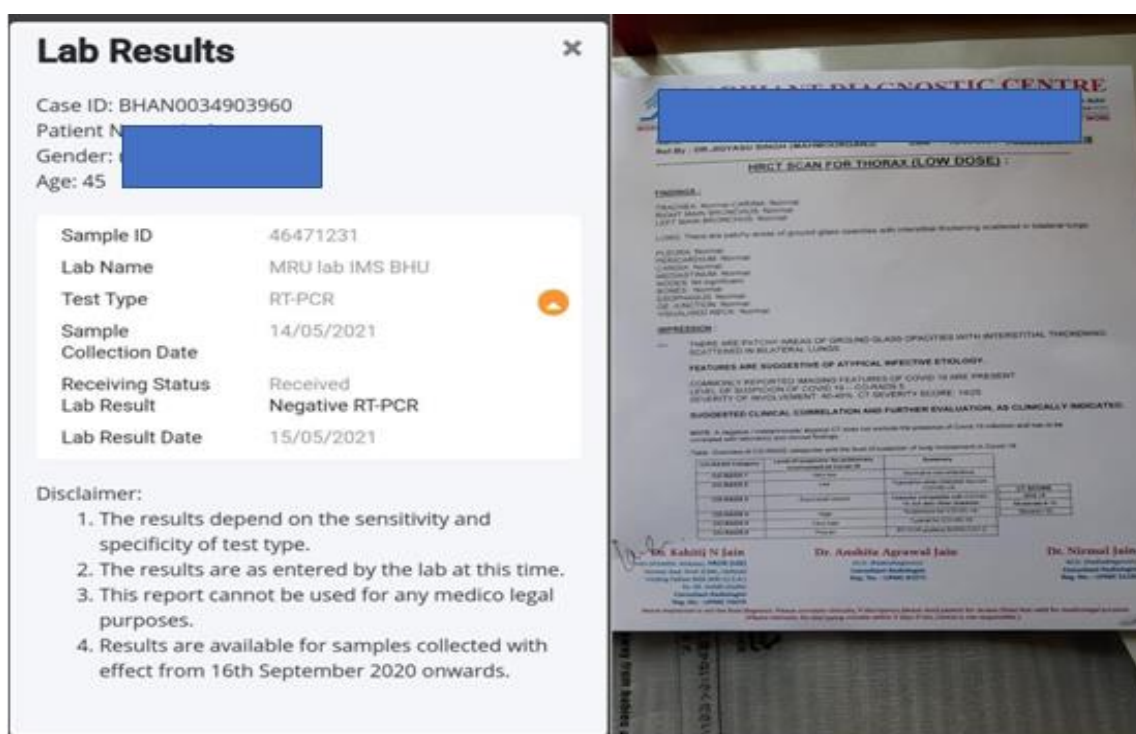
After treatment RT-PCR (14/05/2021), HRCT THORAX (14/05/2021).
